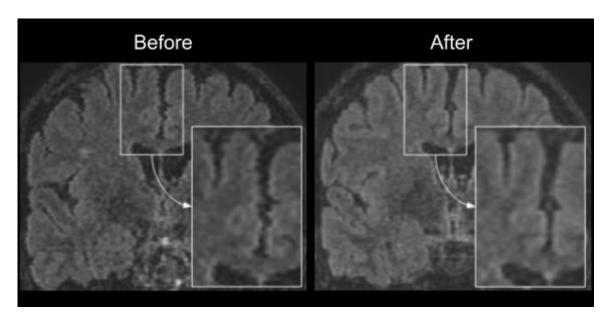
Correction of motion artifacts in FLAIR sequences
